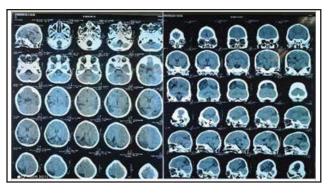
Preoperative CT scan Picture of This CP patient.
